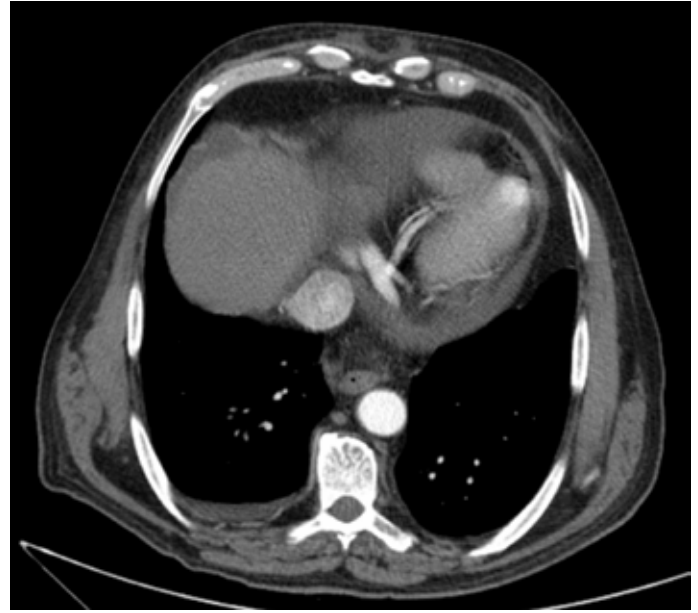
Thorax computed tomography showed giant thrombus filling all right ventricle without any pulmonary artery involvement, and pericardial effusion of 1.98 cm size
